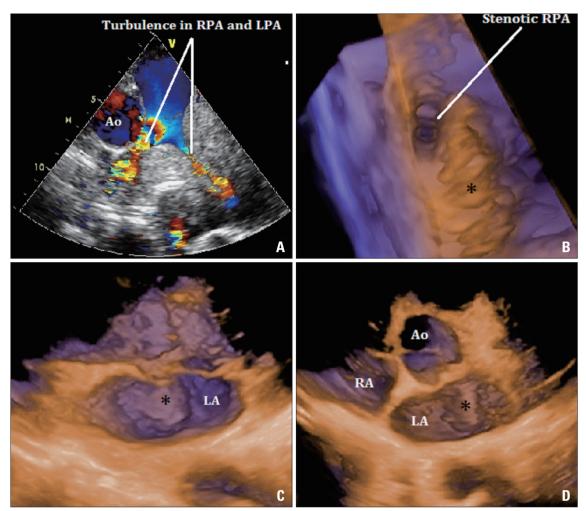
Two dimensional transthoracic echocardiography with color Doppler. The basal short axis (A) view with focus on the pulmonary artery showing severe turbulence in RPA and LPA caused by extrinsic compression of a huge mass. Three dimensional transthoracic echocardiography showing stenotic right pulmonary artery caused by the extrinsic compression by the mass (B) and the surface characteristics and anatomical relationship of the intra atrial extension of the mass (indicated by \* in C and D). Ao: aorta, LA: left atrium, LPA: left pulmonary artery, RA: right atrium, RPA: right pulmonary artery.
